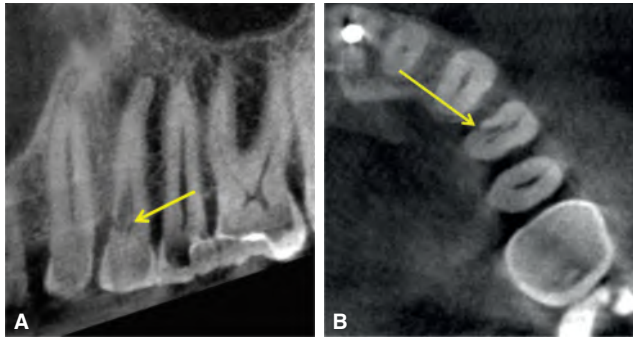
A. CBCT sagittal image showing radiographic evidence of an extensive invasive cervical resorption in a maxillary left first premolar. A characteristic radio-opaque line can be observed at the interface between the image of the resorptive tissue and the dental pulp (yellow arrow). B. CBCT axial view of the same tooth shows the mesio-palatal portal of entry of the resorptive defect (yellow arrow). (Courtesy of Drs. Randolph Todd and Paul Fletcher, New York, NY.)
